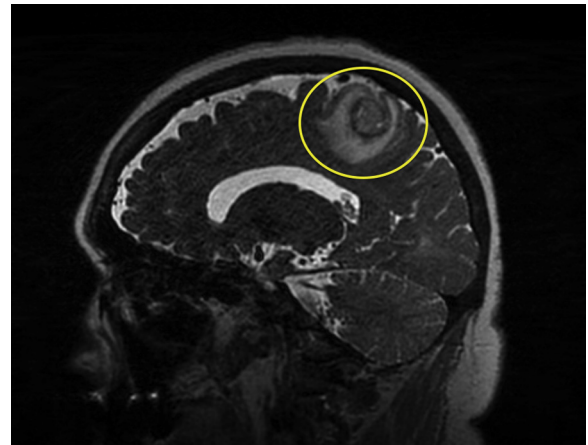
Diffusion tensor imaging with magnetic resonance imaging (sagittal view): The circle encloses the lesion of the left frontoparietal region.
